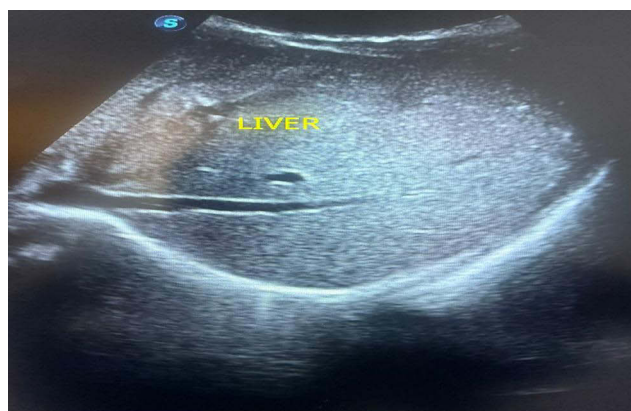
Abdominal ultrasound showing normal liver morphology without biliary obstruction or ascites.
